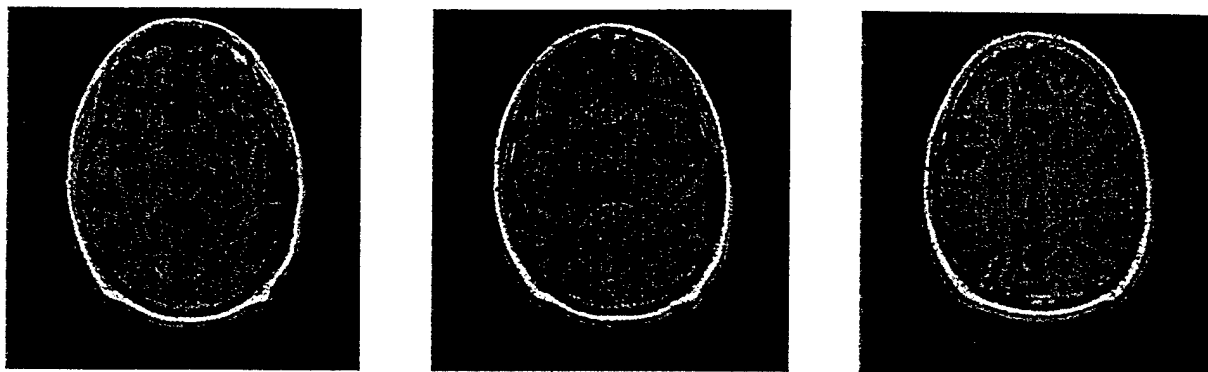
Test sequence of MRI brain scans (original images).
